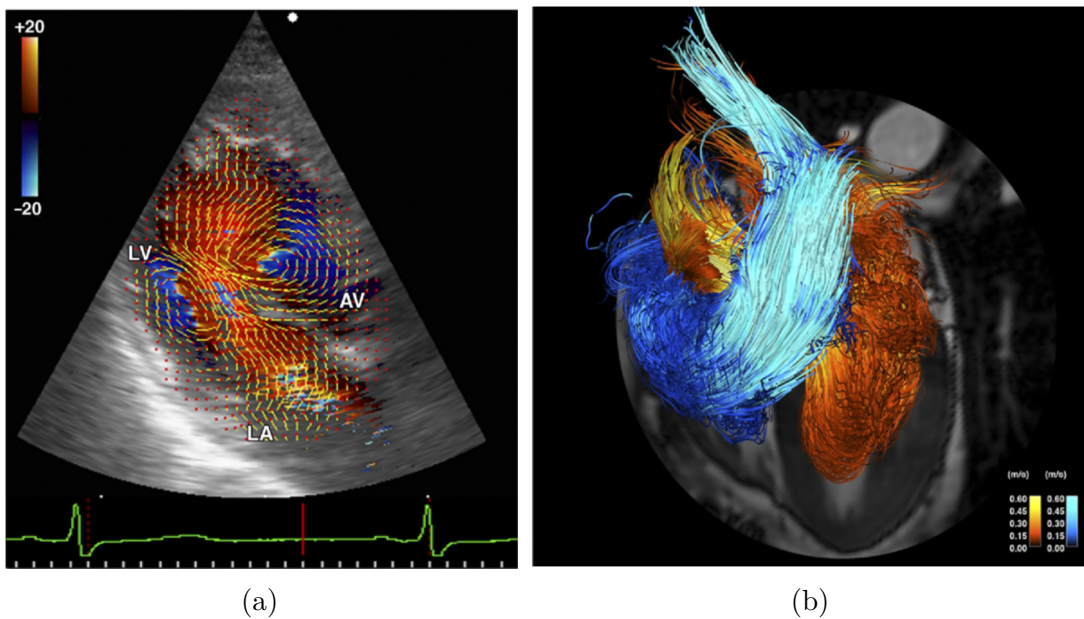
Velocity maps in the heart obtained by a). Vector Doppler echocardiography, and b). phase-contrast MRI. Images are taken from [134].
